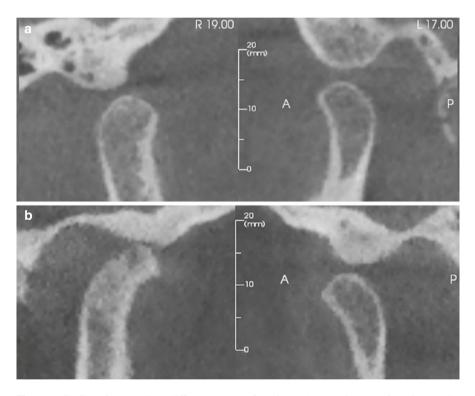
CBCT reformats show different ranges of motion: (a) normal range of motion (at the level of the crest of the eminence); (b) unilateral limitation of condylar translation on the right; (c) bilateral limitation of condylar motion, with the condyles located posterior and superior to the crest of the eminence and in contact with the posterior slope of the eminence; and (d) hypermobility of the left condyle, with the condyle located anterior and superior to the crest of the eminence
